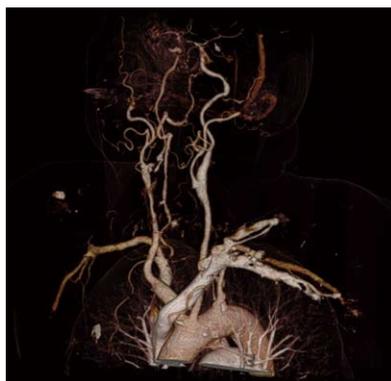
Flash CT dual-energy bone removal head collection showing the carotid arteries.
